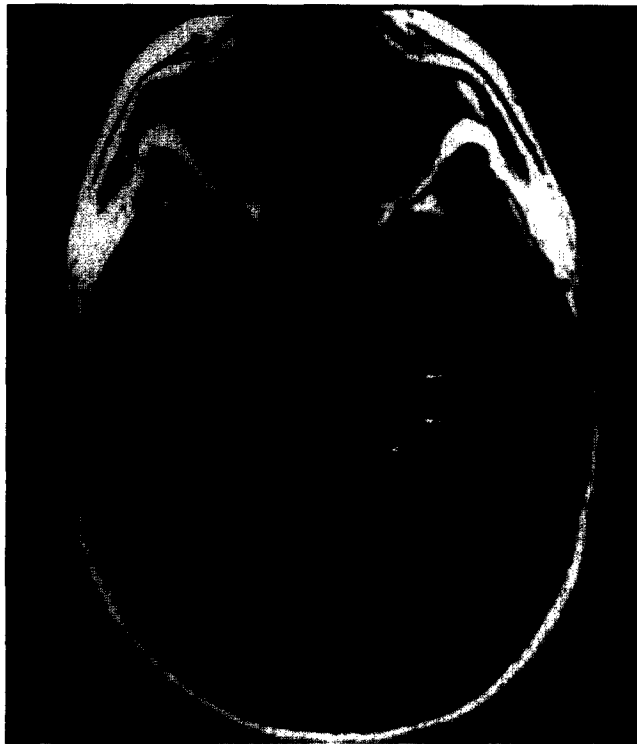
Paired MR/CT studies derived from the validation study. For each study the MR scan is on the top with the corresponding CT below. The left pair shows a normal right hippocampus (readers left side) and a questionably atrophic left hippocampus on both modalities (small white arrows). This case was classified as normal on both modalities. The second pair, classified as atrophic on both modalities, shows bilateral hippocampal formation atrophy (large white arrows).
